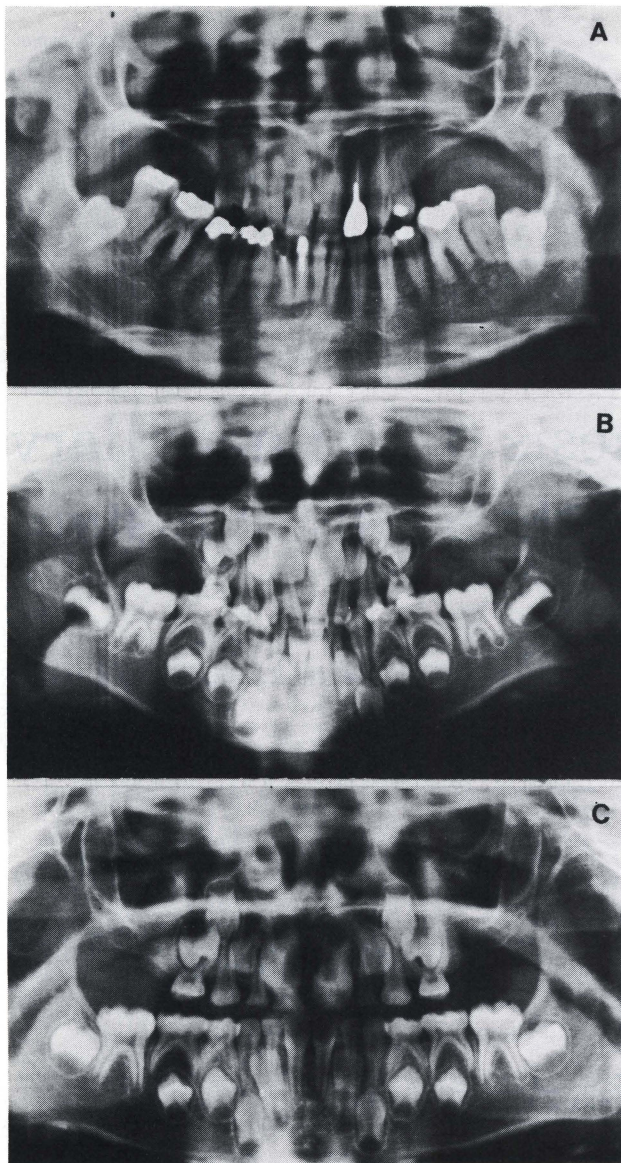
Radiographs of the patients. Mother S.Y. (A), Master J.Y. at the age of 6.2 years (B) and Master T.Y. at the age of 8.1 years (C). Note the similarity of the patterns of the hypodontia and of the upper posterior alveolar processes, in the three radiographs.
